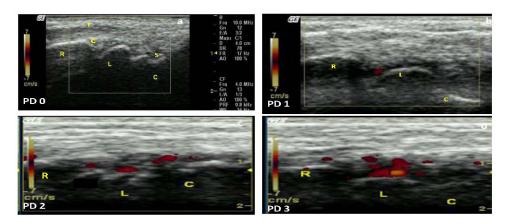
Synovitis identified by power Doppler (PD) ultrasound in a dorsal longitudinal wrist scan. a = grade 0; b = grade 1; c = grade 2; d = grade 3. T = tendon; S = synovitis; R = radius; L = lunate; C = capitate bone; c = cartilage.
